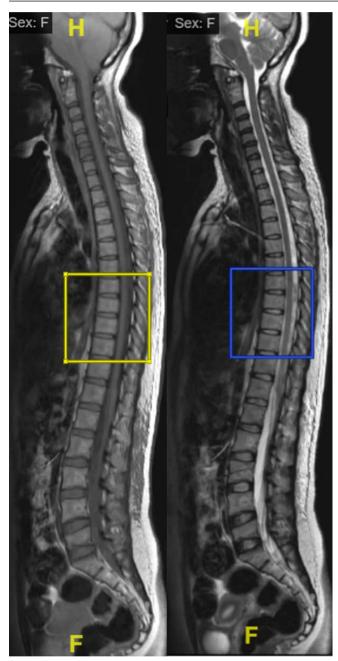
Non-contrast MRI of the whole spine showed multi-focal isointense lesions on T1W and hypointense lesions on T2W in the extramedullary intradural space at levels T7 to T10, suggestive of a subdural hematoma. Comments: yellow box – T1W, blue box – T2W.
